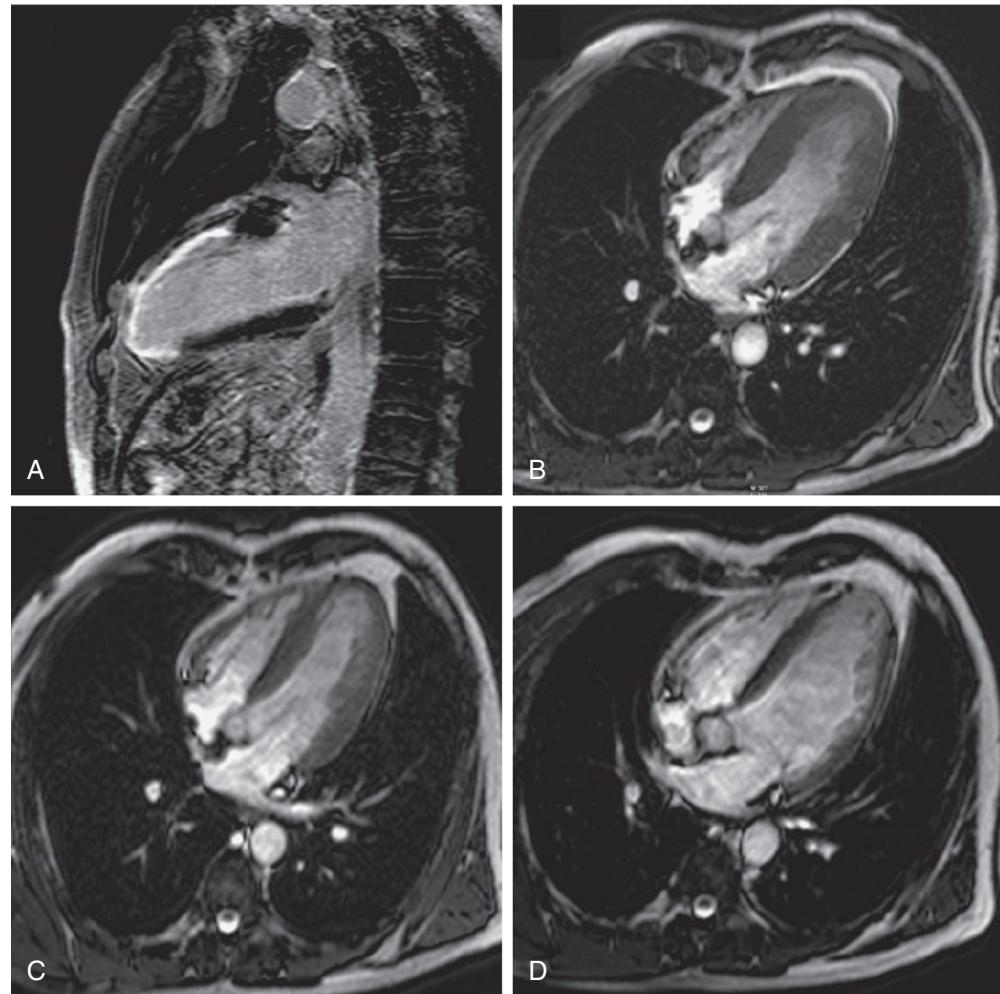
Vertical long-axis delayed-enhancement MRI in a patient with extensive transmural anteroapical MI (A). Horizontal long-axis cine-MRI at baseline (B), at 4 months (C), and at 1 year (D) shows progressive LV dilation (LV end-diastolic volume index of 81.9 mL/m^2 at baseline, 88.2 mL/m^2 at 4 months, and 112.7 mL/m^2 at 1 year) with progressive thinning of the LV wall. (From Ganame J, Messali G, Masci PG, et al: Time course of infarct healing and left ventricular remodelling in patients with reperfused STEMI using comprehensive magnetic resonance imaging. Eur Radiol 21:693, 2011.)
